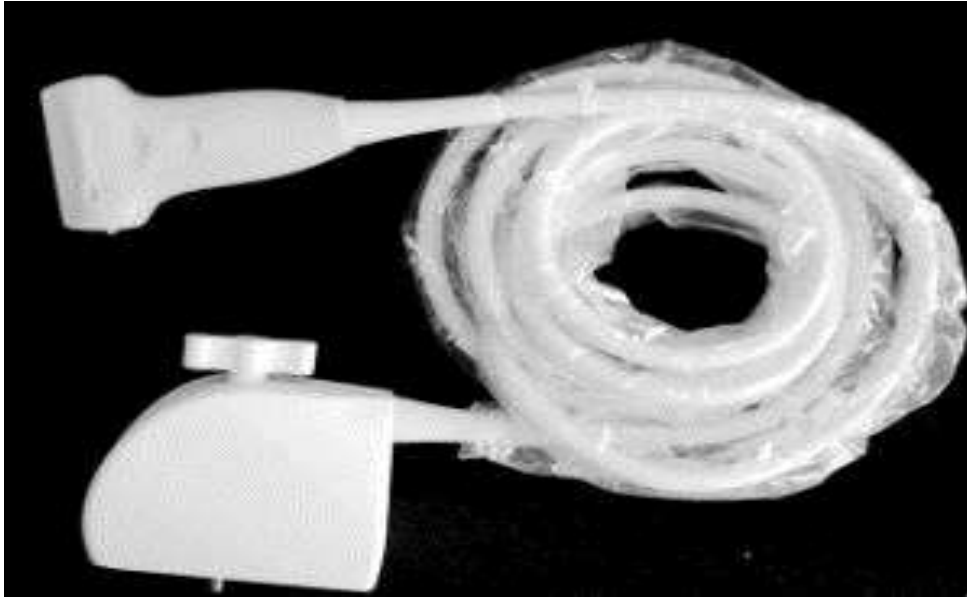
the linear ultrasound probe.
